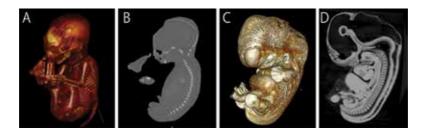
The results of X-ray CT. A, B: Clinical CT (Toshiba Alexion) in the Laboratory of Physical Anthropology, Graduate School of Science, Kyoto University, Japan. C, D: Phase contrast CT, Photon Factory of the KEK (High Energy Accelerator Research Organization) in Tsukuba, Japan. A, C: Surface reconstruction and B, D: midsagittal section.
